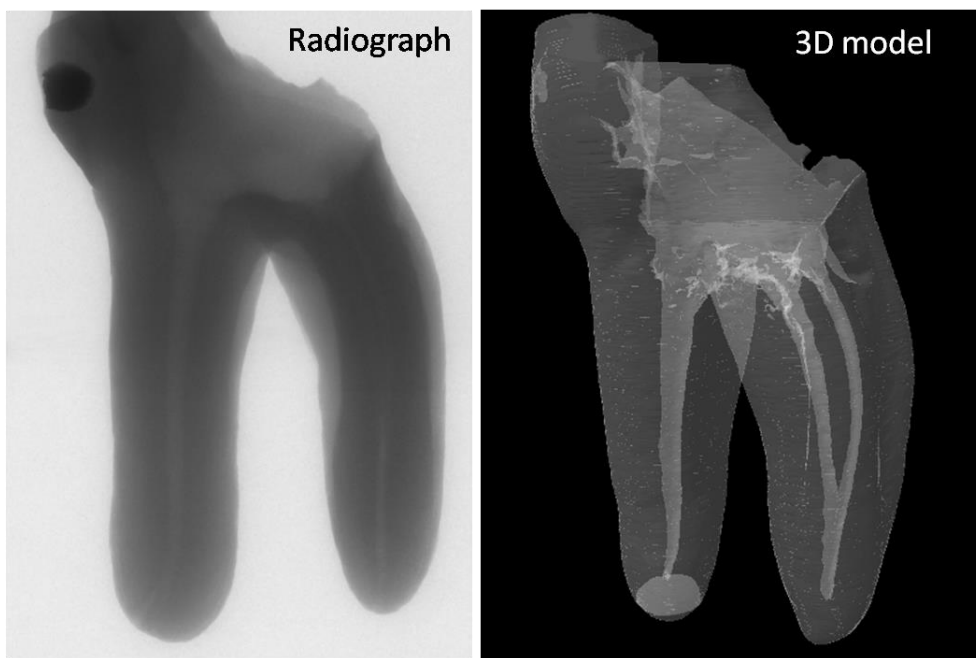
The X-ray image of the tooth and reconstructed 3D model of the same sample
